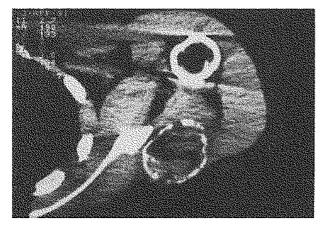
A CT scan of the thorax showing extensive extraskeletal ossification (Patient 4).
